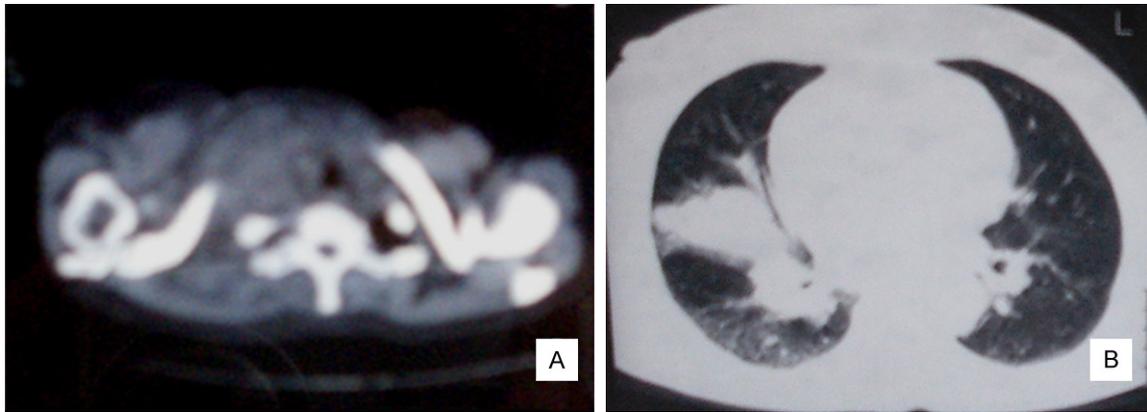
Radiographs of the neck and lung. A. T2-weighted magnetic resonance image of the neck showing multiple tumoral mass invading the surrounding structures. B. Transverse CT photograph showing multiple bilateral lesions with a large tumoral mass surrounded by peripheral ground-glass opacities of right lung and, to lesser extent, of left lung.
